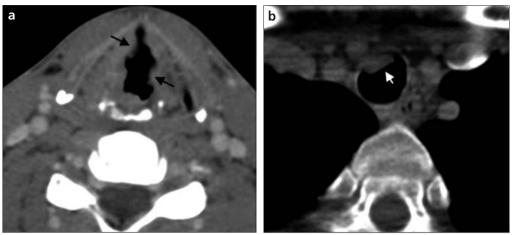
a, b. Axial CT images (a, b) from the levels of larynx (a) and trachea (b). Multiple papillomas protruding into the airway lumen (arrows) are shown.
